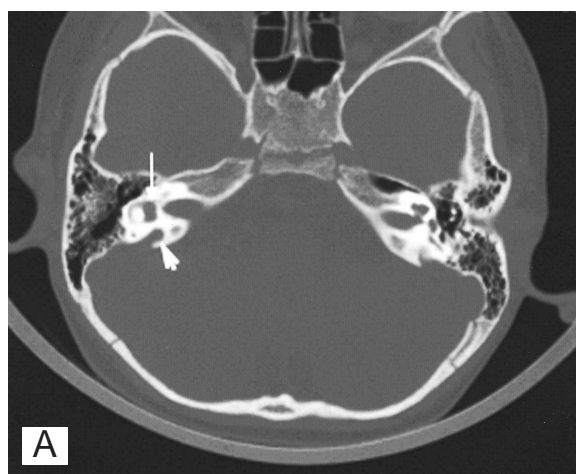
Mastoid CT (axial view). Enlarged vestibular aqueduct (short arrow) and widening vestibule (long arrow). A: Right. B: Left.
